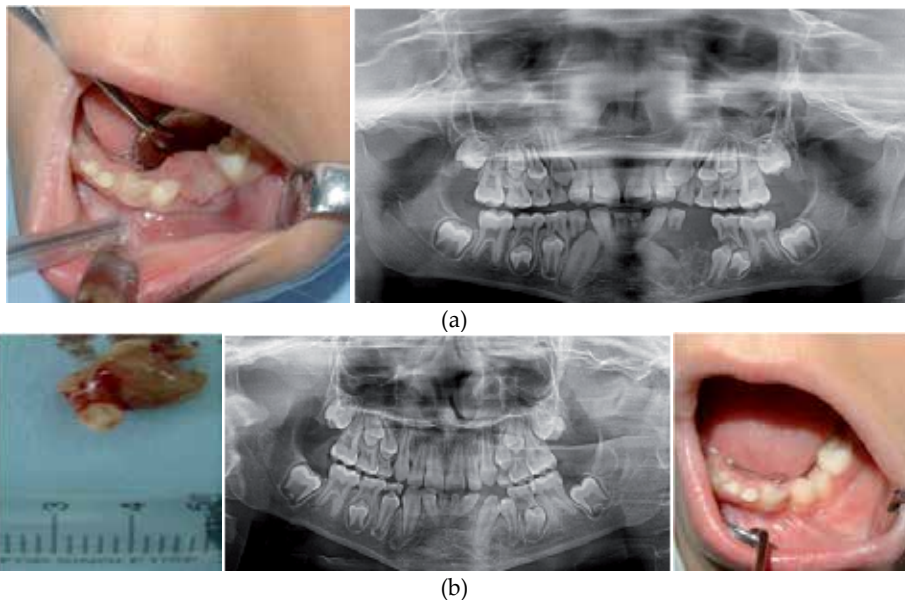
(a). CGCG: Photograph showing a 13-year-old boy presenting a posterior mandibular lesion at premolar region (a): Preoperative facial view showing ulcerative mass (left); Preoperative radiograph showing the lesion. (b): Excised pathologic mass associated with tooth ; Postoperative panoramic radiograph showing normal bone pattern. Clinical view taken 13 months post-operatively
